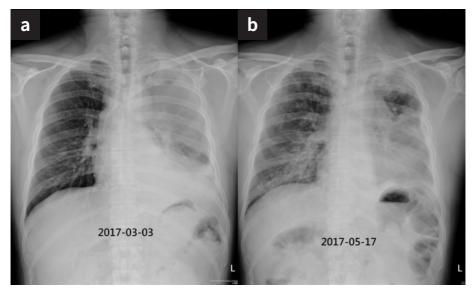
Chest radiography (03-03-2017 and 05-17-2017) after two cycles of pembrolizumab.
